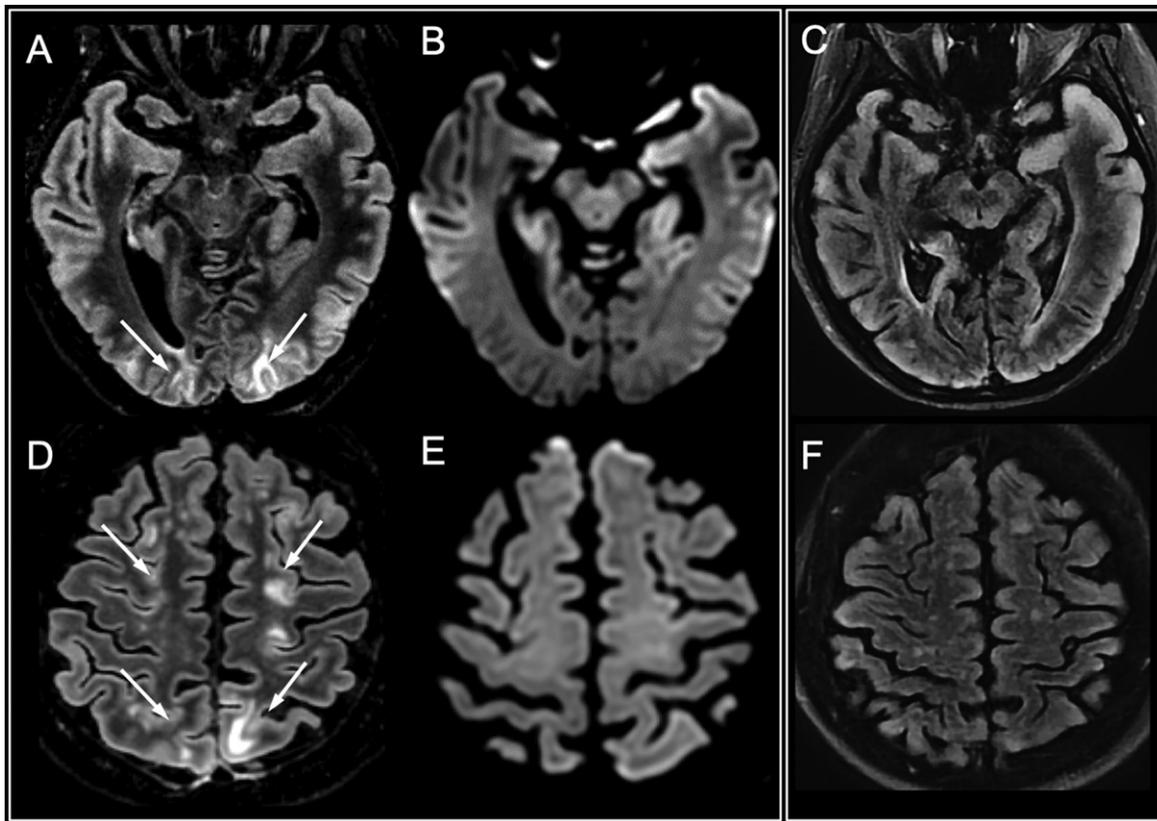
Posterior reversible encephalopathy syndrome. A 66-year-old man infected with severe acute respiratory syndrome coronavirus 2 presented with status epilepticus in the context of pneumonia and severe hyponatremia. A, D, Corticosubcortical signal abnormalities in the parieto-occipital and superior frontal regions on fluid-attenuated inversion recovery images (arrows), with, B and E, no diffusion restriction. C and F, Follow-up MRI performed 10 days later showed complete disappearance of the lesions.
